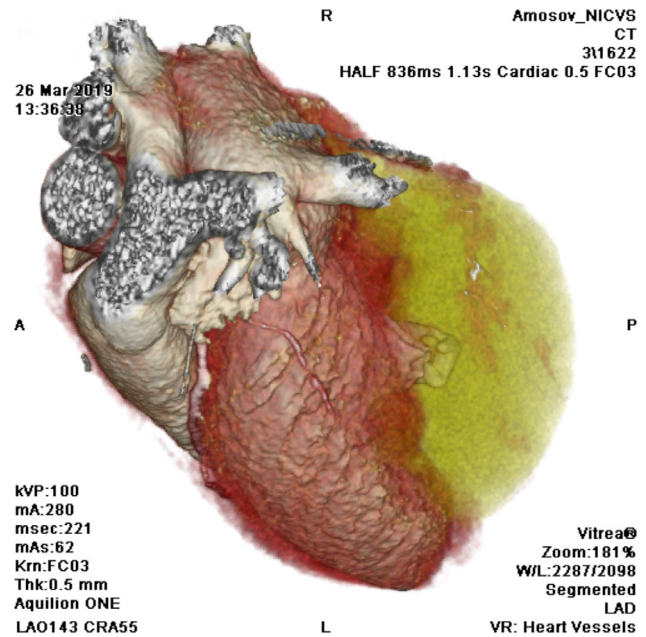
Three-dimensional reconstruction of a cardiac CT study demonstrates the leak of contrast medium into a giant tumor of the LV with a fat density (marked in yellow)
